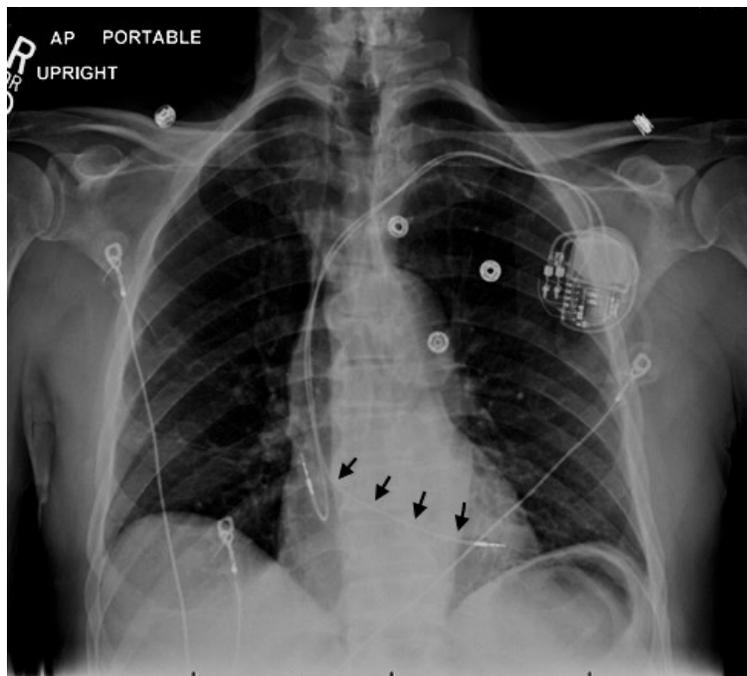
Post-operative portable chest X-ray; arrowheads indicate the ventricular lead.
